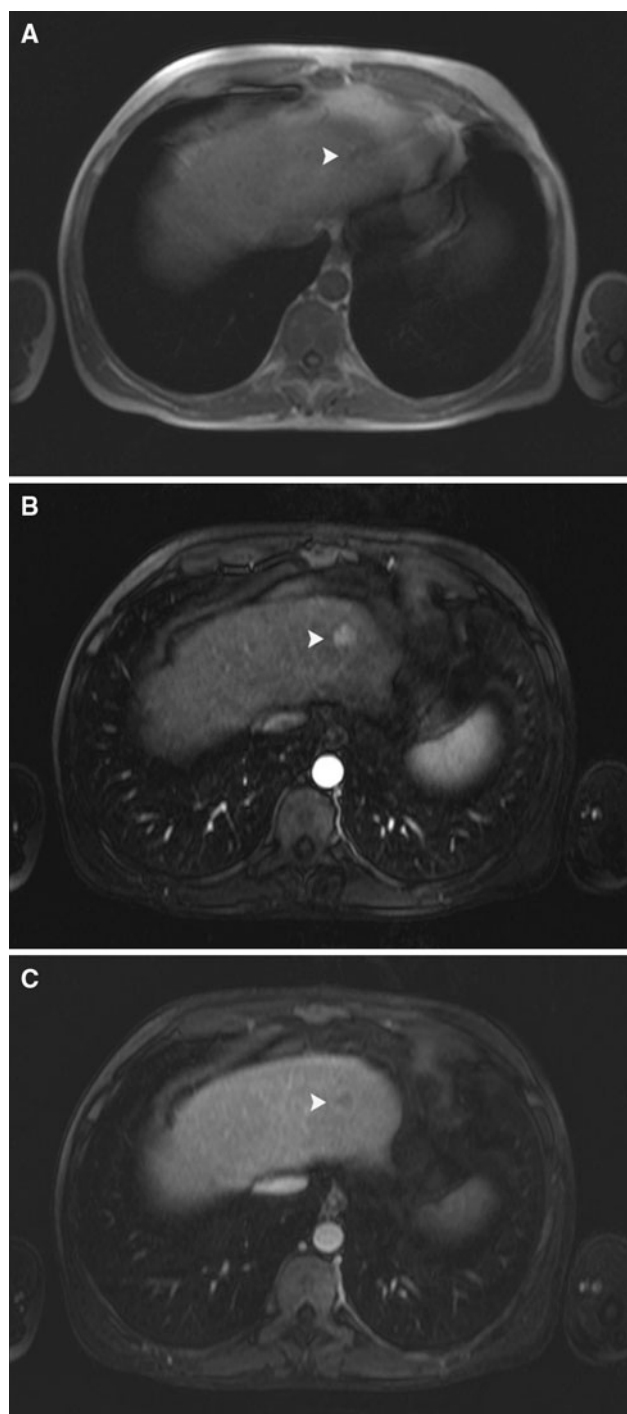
Well-differentiated HCC 14 mm in size located in the lateral segment of the left hepatic lobe, in a patient with liver cirrhosis. The lesion displays the typical vascular profile of HCC. A MRI shows a slightly hypointense nodule (*arrowhead*) in the T1WI. B The lesion shows a dramatic homogeneous arterial enhancement (wash-in pattern), C with a clear decrease of signal intensity compared to the surrounding liver parenchyma in the portal venous phase (washout) (*arrowhead*).
